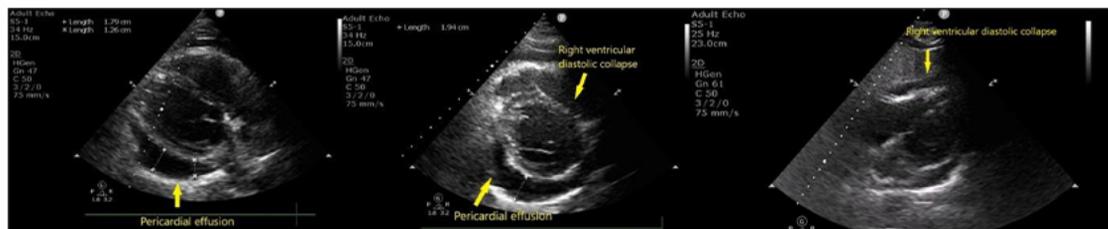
Two-dimensional echocardiographic still images. Left: subcostal view showing global pericardial with right ventricular diastolic collapse. Center: short-axis view showing large global pericardial effusion with right ventricular diastolic collapse. Right: parasternal long-axis view showing global pericardial effusion, more towards the inferior side, marked by arrow.
